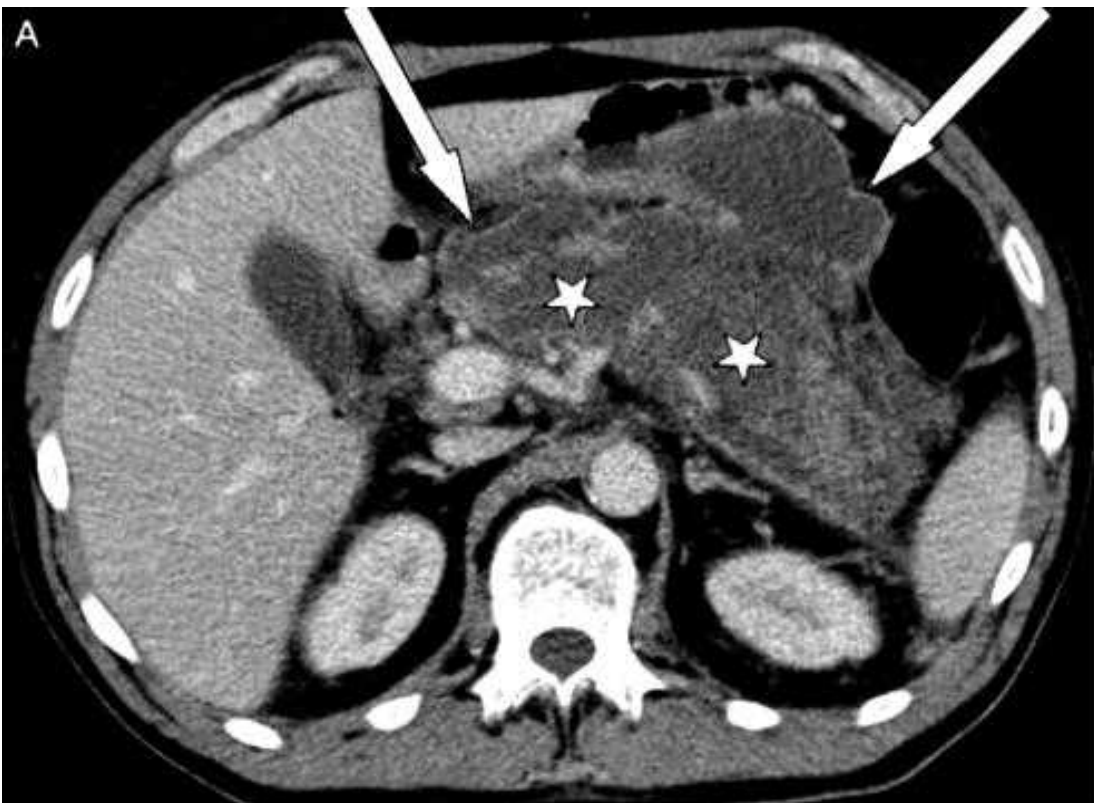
CT image of Necrotising pancreatitis
